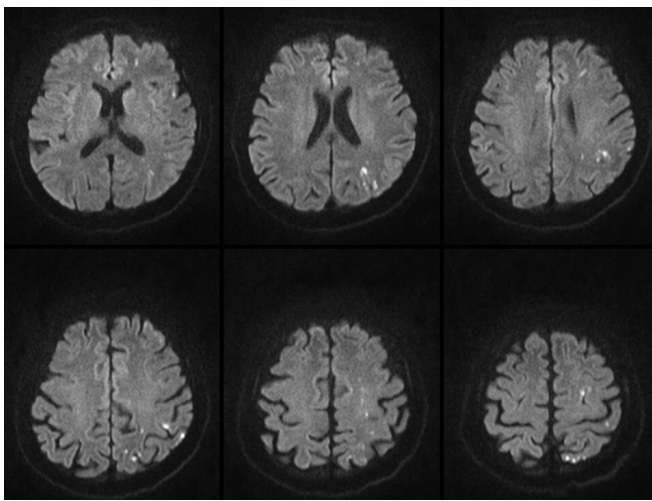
Diffusion magnetic resonance image of the first postoperative day showed multiple high embolic signals, but the patient was asymptomatic.
